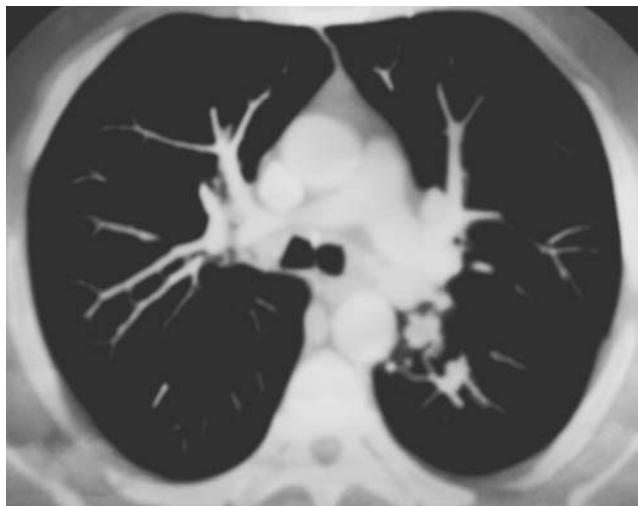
CT image of the left hiliar mass
